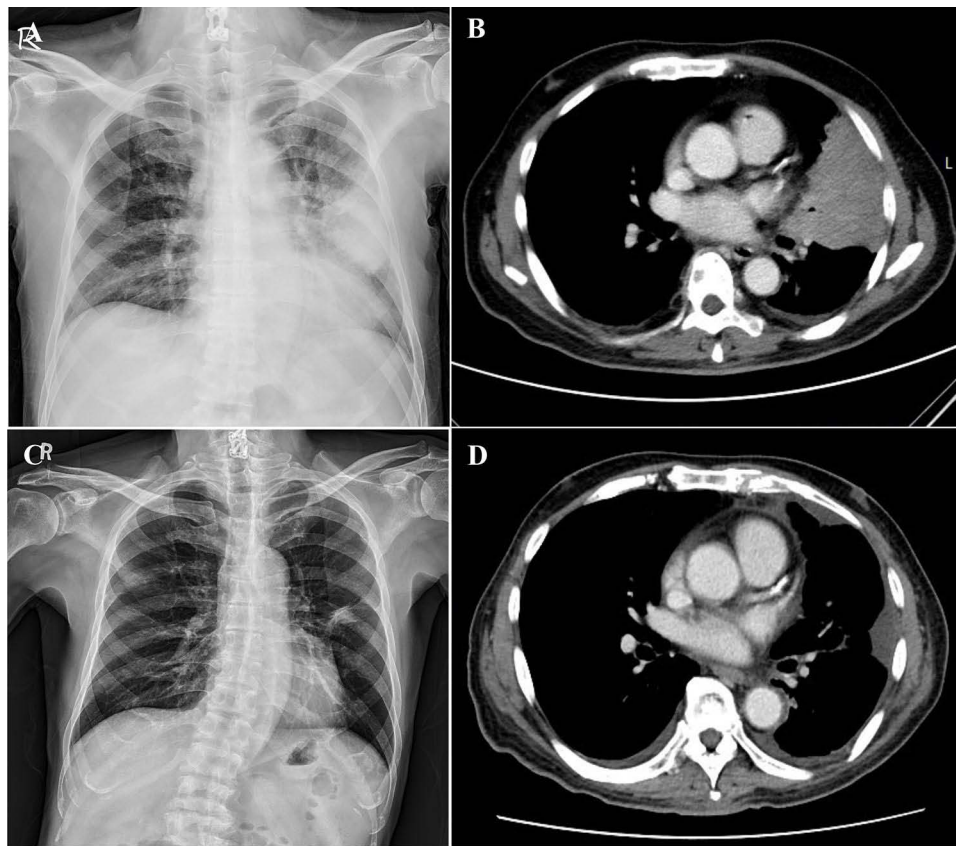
Radiographic findings before and after dacomitinib treatment. (A) Chest X-ray showed a mass-like opacity in the left lung field. (B) CT scan displayed a 7×7 cm mass in the left upper lobe, with enlarged contralateral mediastinal lymph nodes and evidence of multiple bony metastases. (C) Chest X-ray and (D) CT scan revealed a reduced lung tumor size in the left upper lobe after dacomitinib therapy.
